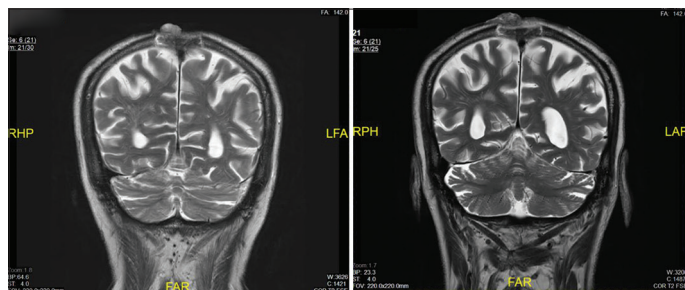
Magnetic resonance imaging brain prior and post-irradiation evaluation indicating no observable change in the size of the lesion
